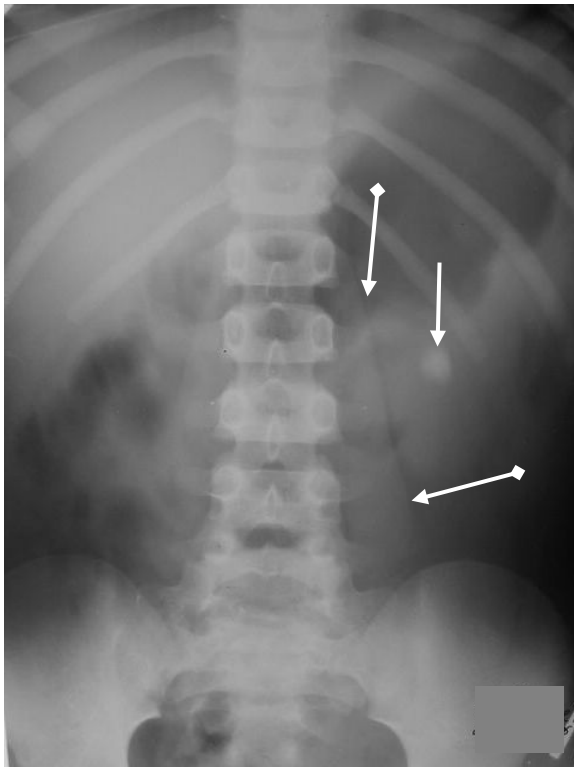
X-ray film of the abdomen cavity. The intensive spherical shadow with precise contours is detected in the area of a left kidney (arrow). Psoas (arrows with a rhombus). A stone. Urolithiasis
